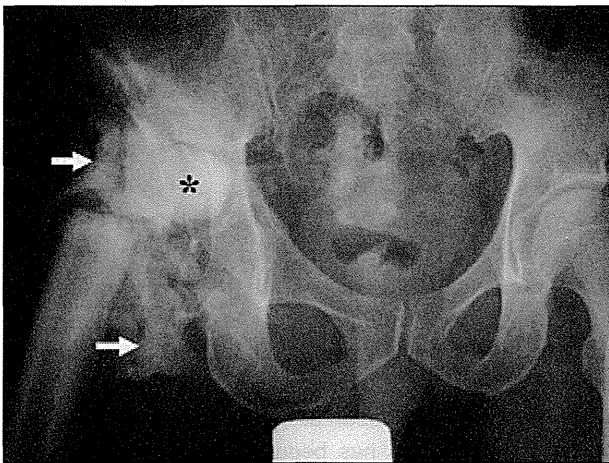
An AP radiograph of the hip joint. The proximal femur was resected, and the proximal stump was at the isthmus. White arrows represent ectopic ossifications. Asterisk represents cement spacer.
